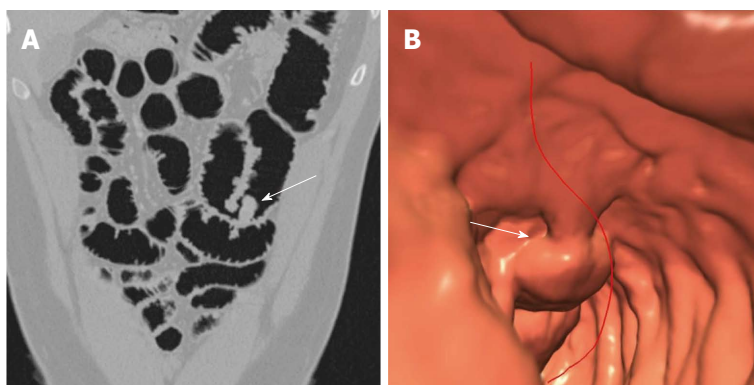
Twenty-eight-year-old male with a known peutz-Jeghers syndrome presenting a single small-bowel polyp. A: Multidetector row computed tomography-virtual endoscopy (MDCT-VE) acquired after gas filling shows a single polyp in the intestinal lumen (arrow); B: Corresponding image of this polyp after MDCT-VE post-processing (arrow).
